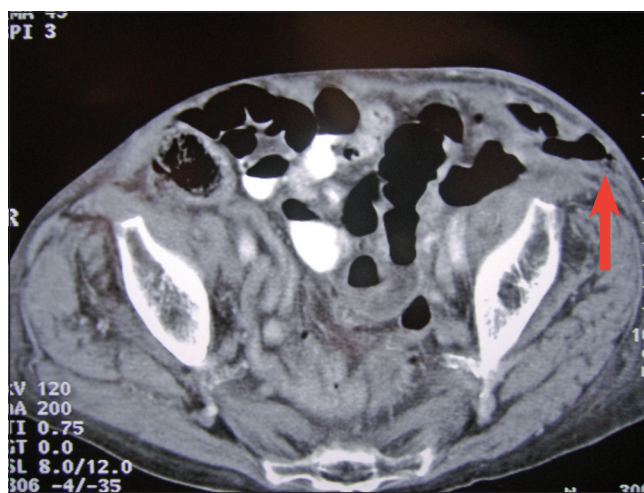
CT scan showing inflammatory changes with stranding of the subcutaneous fat in the left groin and a large bowel diverticulum
